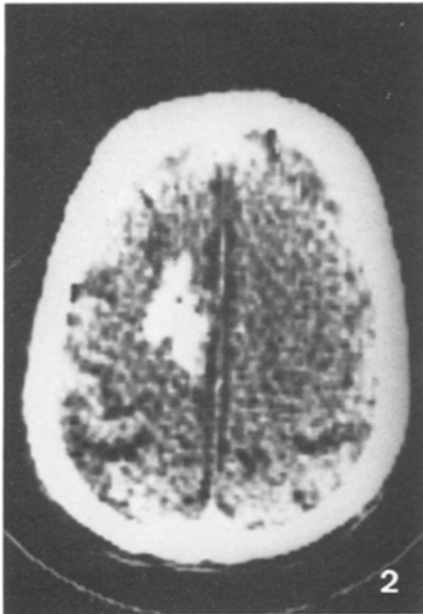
CT scan in Case 1, showing a left paramedian parietal hyperdensity with partial peripheral enhancement after contrast medium injection
